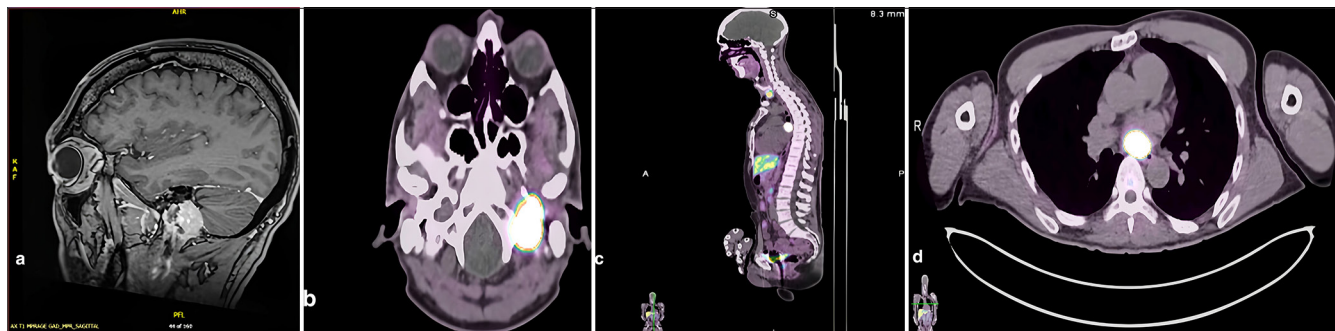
A 55-year-old man with multifocal paragangliomas involving the skull base and mediastinum. (a) Sagittal post-contrast magnetic resonance imaging shows an enhancing mass centered at the left jugular foramen. (b) Axial 68Ga-DOTATATE positron emission tomography-computed tomography (PET-CT) demonstrates somatostatin-receptor-avid left jugular foramen lesion. (c) Sagittal 68Ga-DOTATATE PET-CT reveals a subcarinal lesion with mild indentation of the left atrium. (d) Axial 68Ga-DOTATATE PET-CT confirms an avid subcarinal paraganglioma abutting the posterior left atrial wall.
